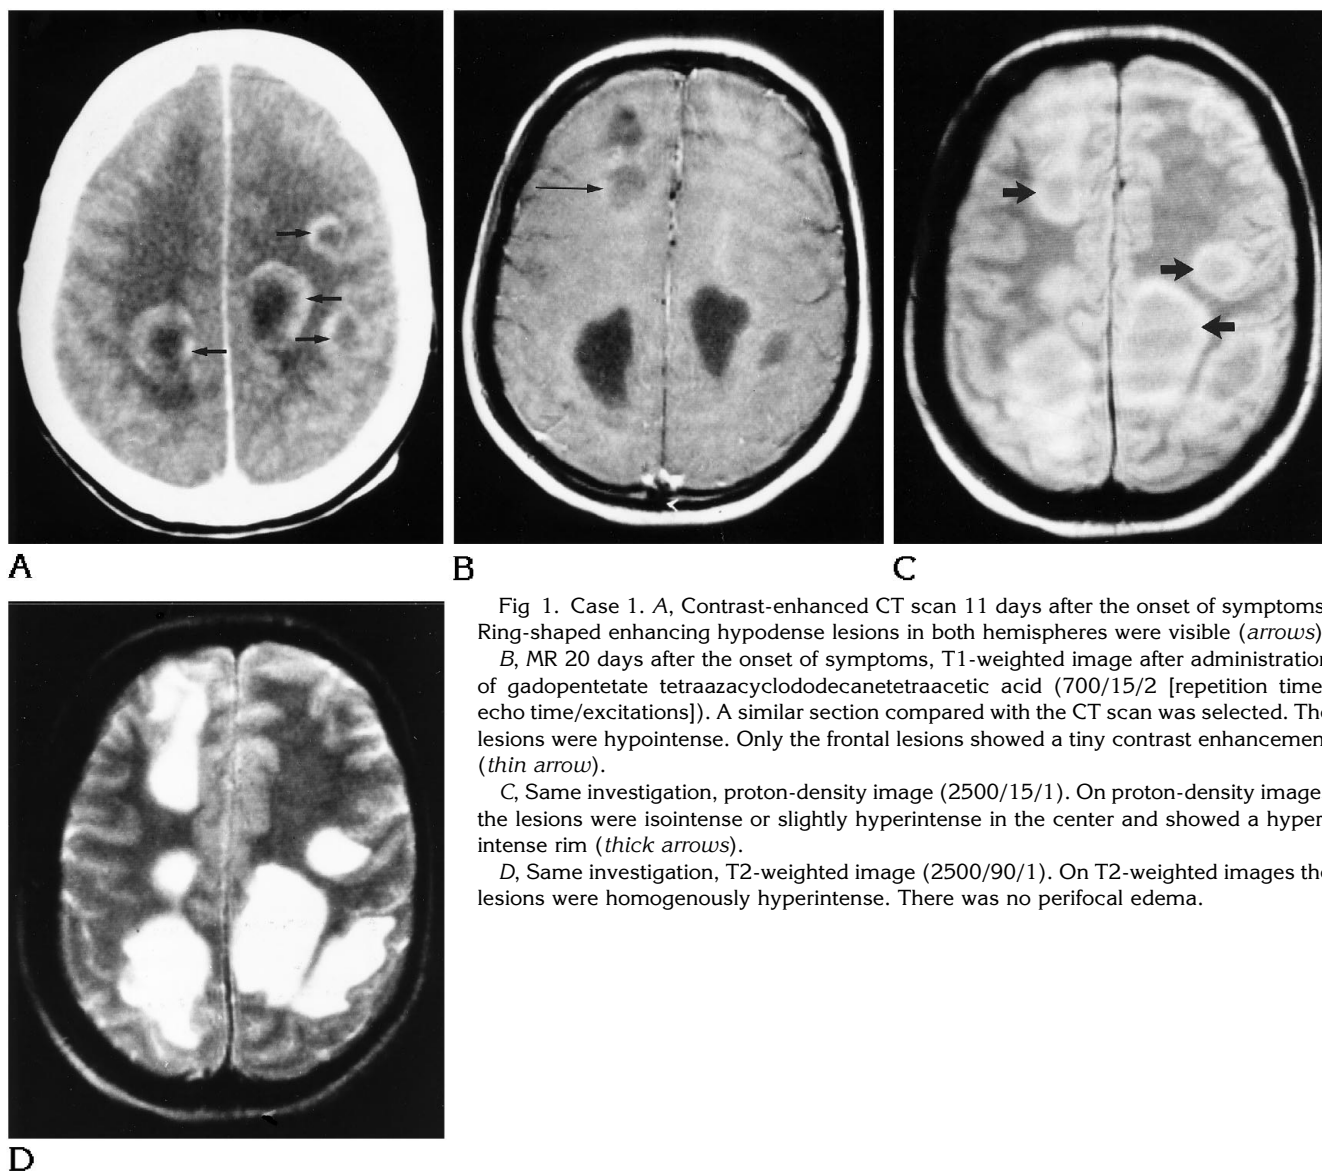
Case 1. A, Contrast-enhanced CT scan 11 days after the onset of symptoms. Ring-shaped enhancing hypodense lesions in both hemispheres were visible (*arrows*). B, MR 20 days after the onset of symptoms, T1-weighted image after administration of gadopentetate tetraazacyclododecanetetraacetic acid (700/15/2 [repetition time/echo time/excitations]). A similar section compared with the CT scan was selected. The lesions were hypointense. Only the frontal lesions showed a tiny contrast enhancement (*thin arrow*).
